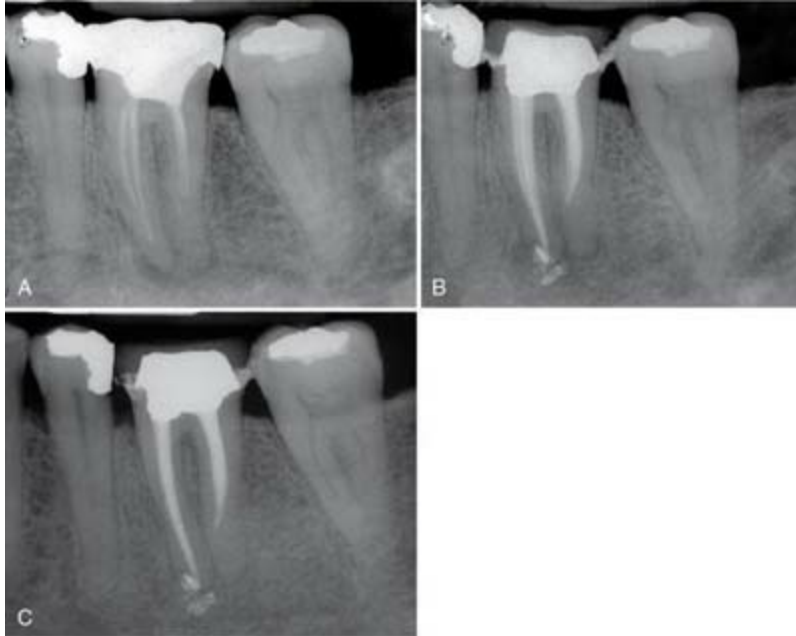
A, Preoperative radiograph showing mesial canal blockages and potential distal root ledging with accompanying posttreatment disease. B, Final film showing mesial blockages bypassed but inability to negotiate beyond the distal ledge. The patient elected to pursue no further treatment at this time. C, One-year recall. Despite not achieving all the aims of conventional endodontic therapy, periradicular healing is apparent. The patient is asymptomatic and will now begin the final restoration with the knowledge that apical surgery may be needed in the future.
